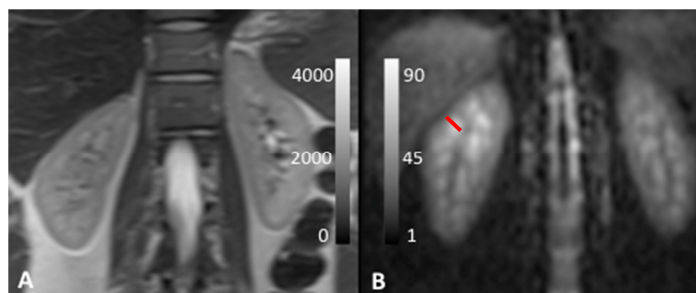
A. coronal T2-weighted image acquired only from one healthy volunteer at 3T for comparison with the corresponding B. coronal ²³Na SNR map where the red line represents an ROI evaluation of the corticomedullary gradient.
